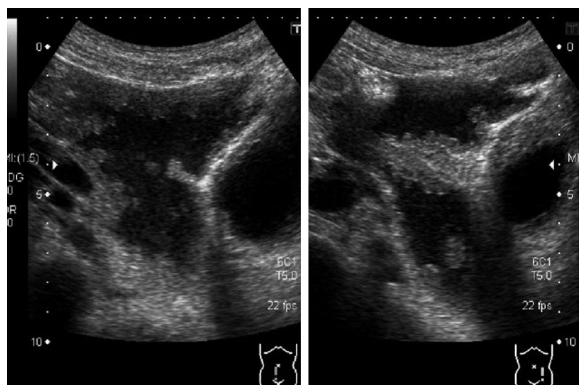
Abdominal ultrasonography. Moderate amount of ascites, irregular thickening of the mesentery and peritoneum, and multiple nodules were observed.
